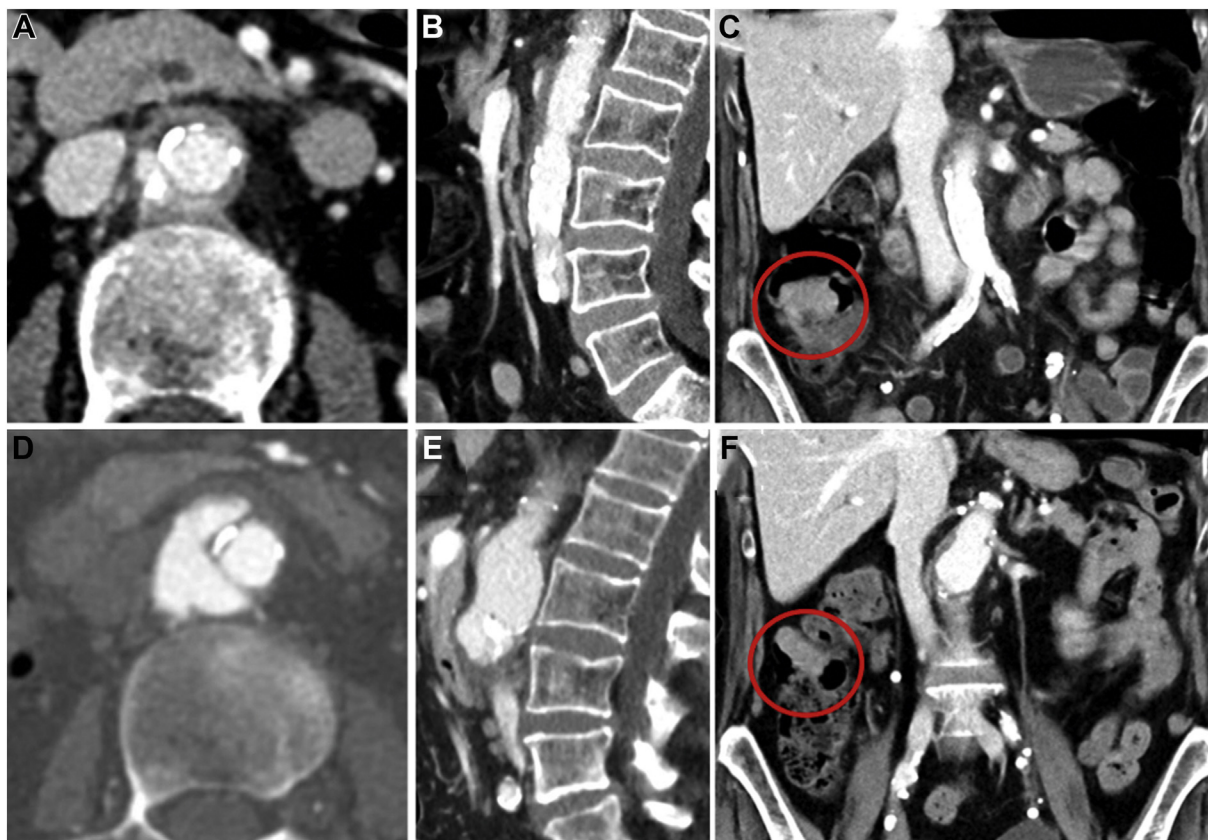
Computed tomography (CT) scans at diagnosis (A-C) and at 3 months of follow-up (D-F). After 3 months of antibiotic treatment, progressive aneurysmatic growth (+12 mm) of the juxtarenal aorta was found with a wide penetrating ulcer and dissection of the outermost vessel layers at a craniocaudal expansion of 5 cm. The tumorous structure in the right colon is highlighted with red circles (C and F).
